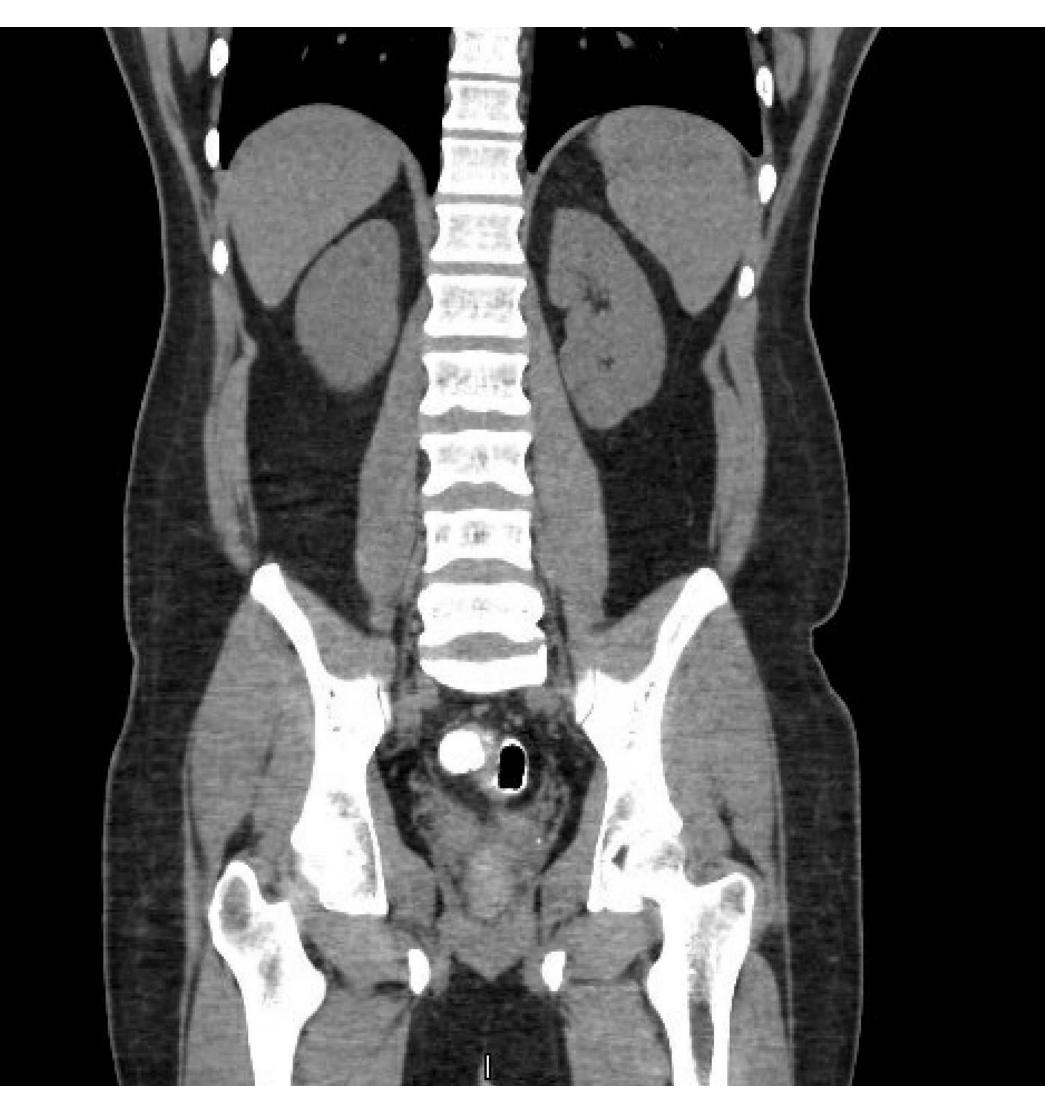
Colovesical Fistula as seen on CT.
